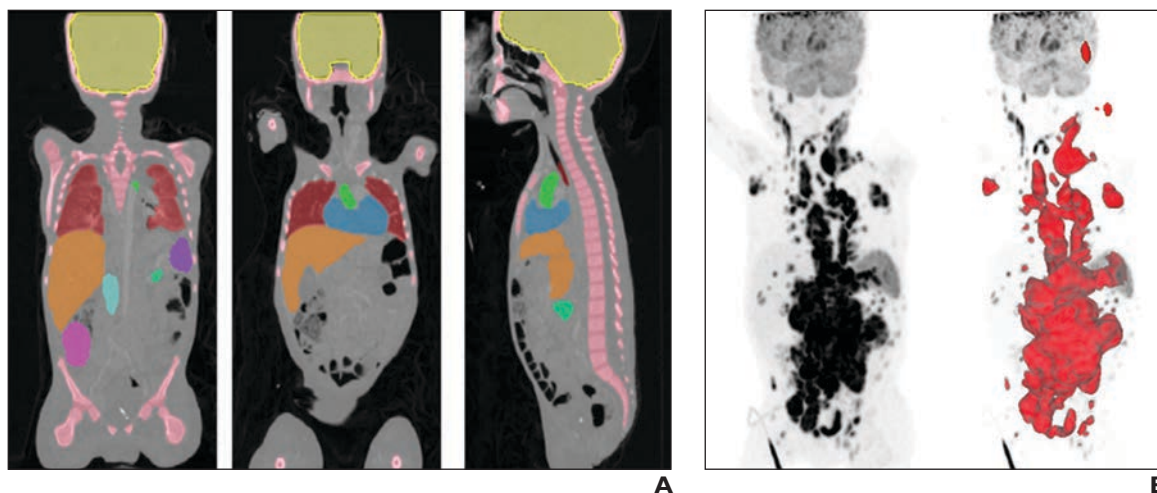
5-year-old boy with posttransplant lymphoproliferative disorder (PTLD), evaluated by FDG PET/CT.
